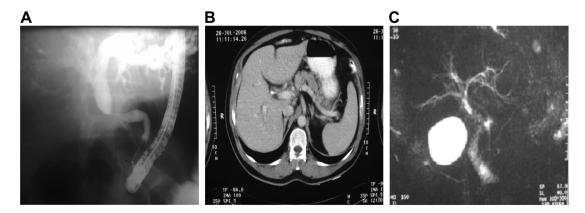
Imaging studies. (A) Endoscopic retrograde cholangiopancreatography showing the mid common bile duct stricture. (B) Computed tomography scan of the abdomen showing intrahepatic bile tract dilatation. (C) Magnetic resonance cholangiopancreatography showing the tapered stricture of the distal common bile duct.
